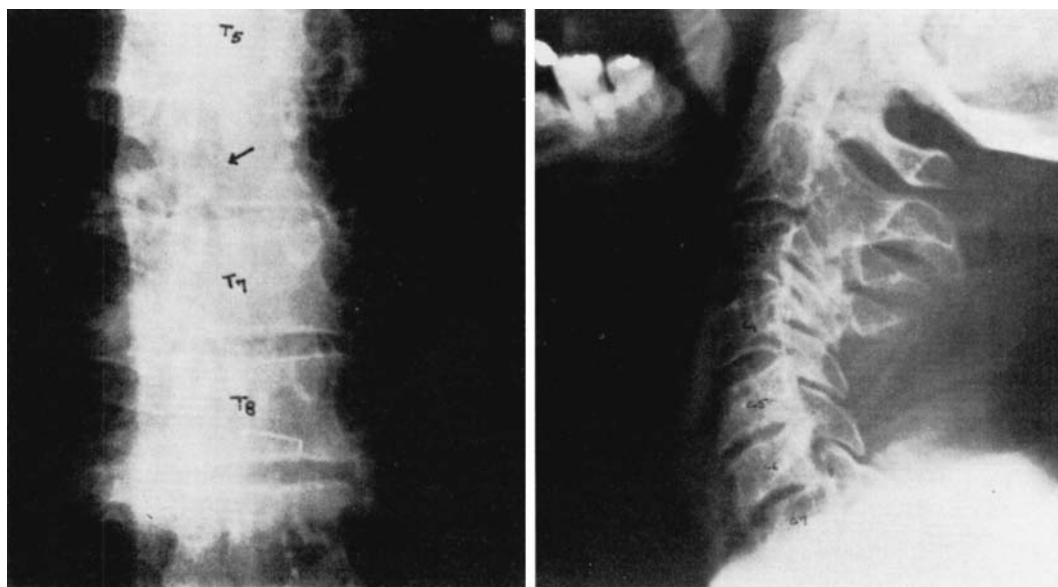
(Case 1). A. Left—x-ray thoracic spine, approximately 1 month following injury, reveals compression fracture of T₆ vertebral body with splitting of the vertebral body. B. Right—x-ray of cervical spine 12 weeks following injury, and after sitting has been allowed, reveals subluxation of C₆ vertebral body on C₇.
